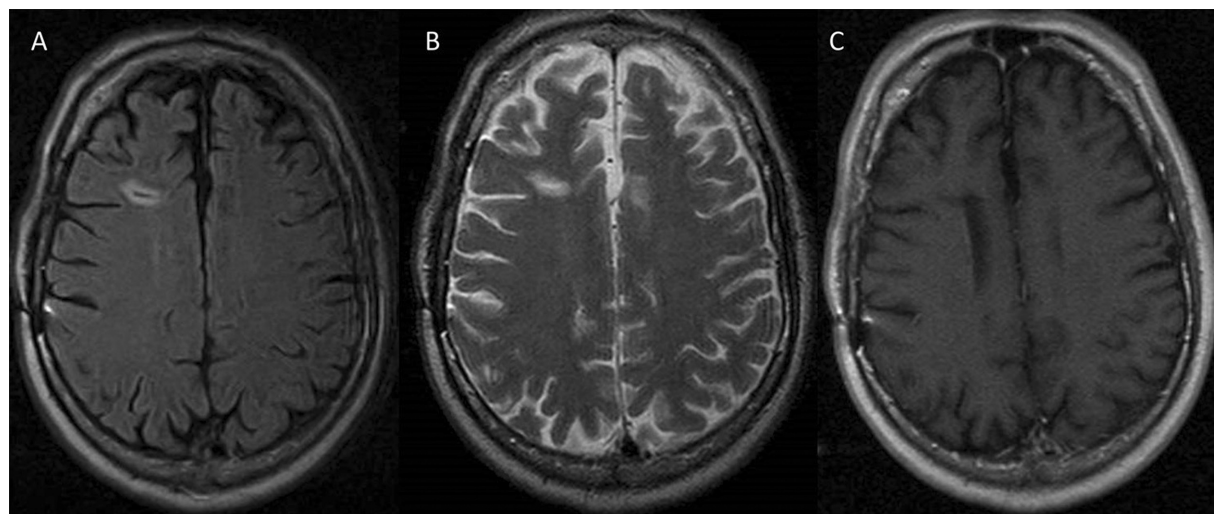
(A–C) Axial T2 FLAIR, T2, and T1 postcontrast MRI at 1 year showing complete resection without recurrence. FLAIR, fluid-attenuated inversion recovery; MRI, magnetic resonance imaging.
